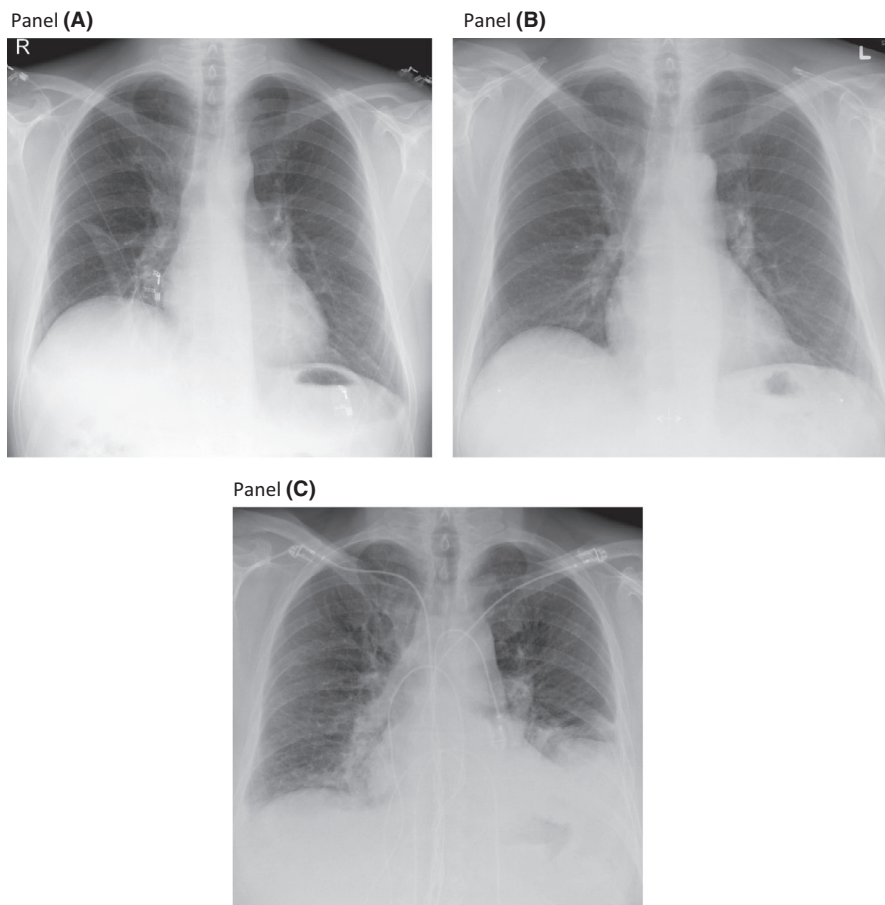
Chest X-rays of the presented patient. Panel A, Elevated right-sided diaphragm after cryoballoon ablation (2005). Panel B, Recovery of the right diaphragm's position, performed before radiofrequency redo pulmonary vein isolation (2017). Panel C, Elevated left-sided diaphragm after redo radiofrequency ablation, with signs of cardiac decompensation and right infrahilar consolidation (2017)
